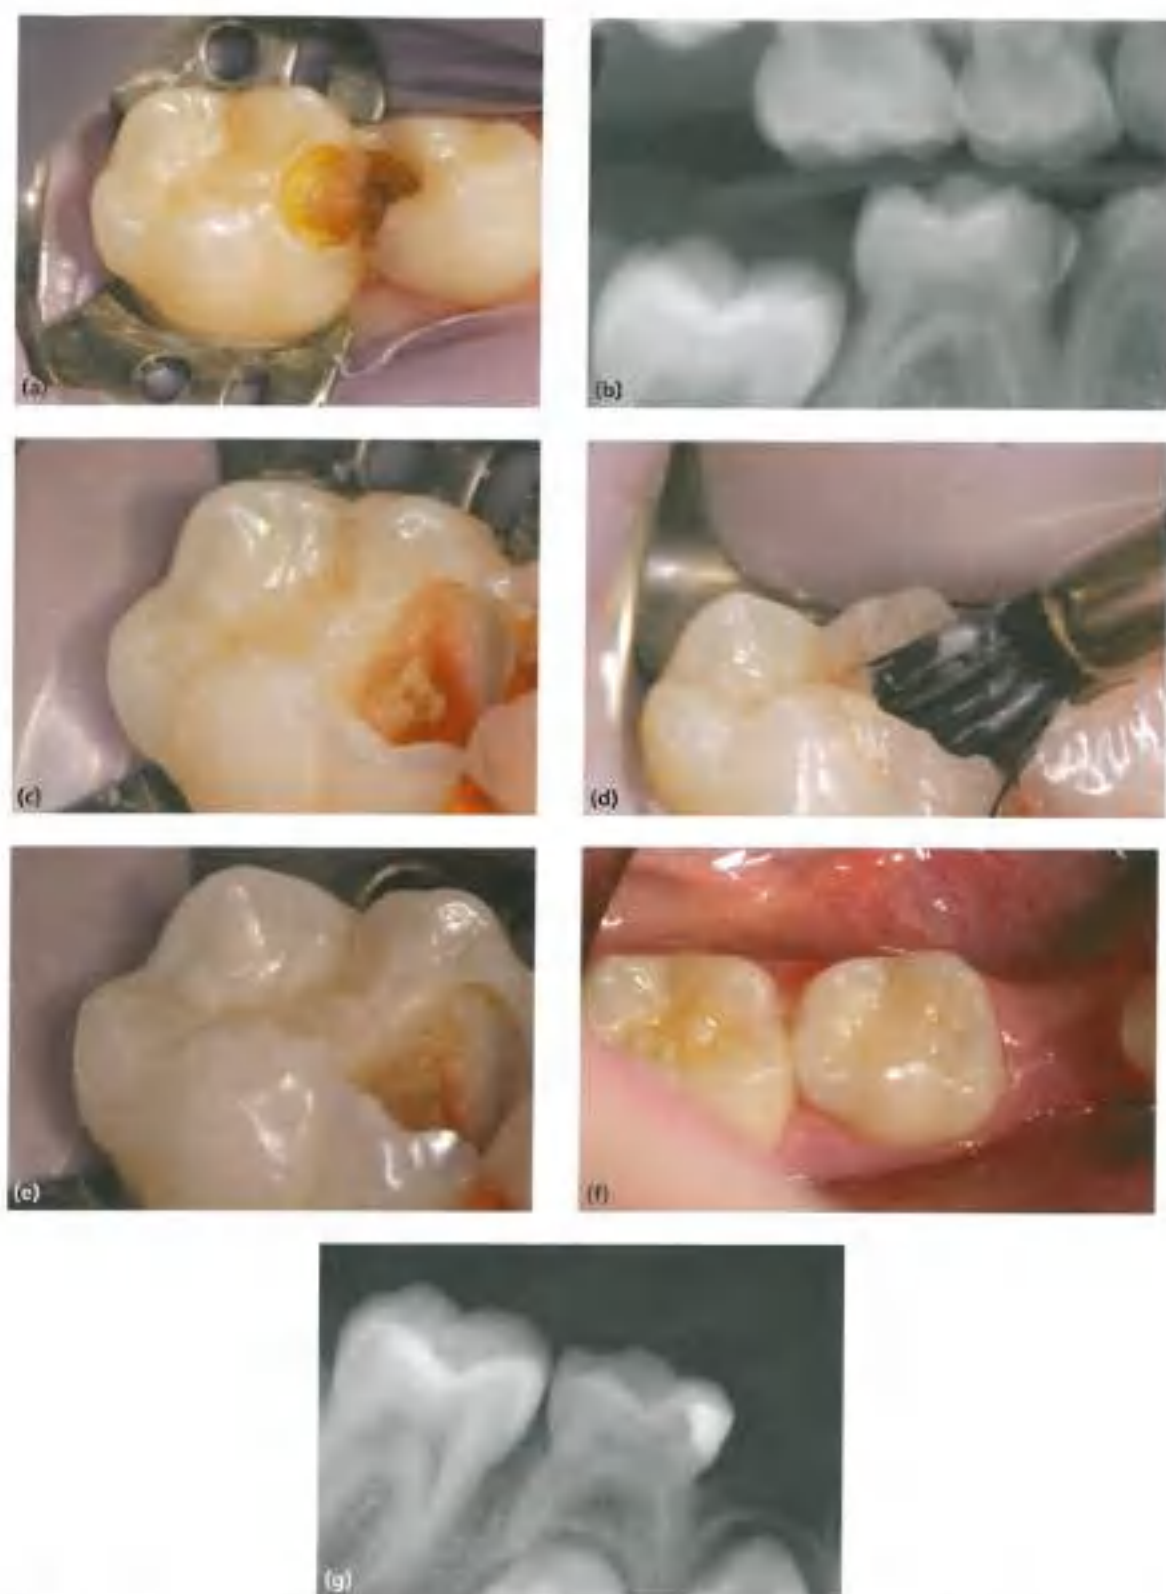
Indirect pulp capping. (a) Deep carious second lower deciduous molar before indirect pulp treatment. (b) Same tooth on bitewing. (c) After excavation of the dentin–enamel junction. The biomass is still present in the center of the cavity. (d) Removing biomass with a rotating prophyl brush and fluoride toothpaste only. (e) After removing the biomass. Next the cavity was dried, a resin-modified glass-ionomer liner (Vitrebond/3 M Espe) was applied, and the cavity was restored with a compomer (Dyract/Dentsply Caulk). (f) Clinical result after 2 years and 4 months. (g) Radiographic result after 2 years and 4 months. Courtesy of René Gruythuysen and BSL, Springer Media, Houten, The Netherlands.
